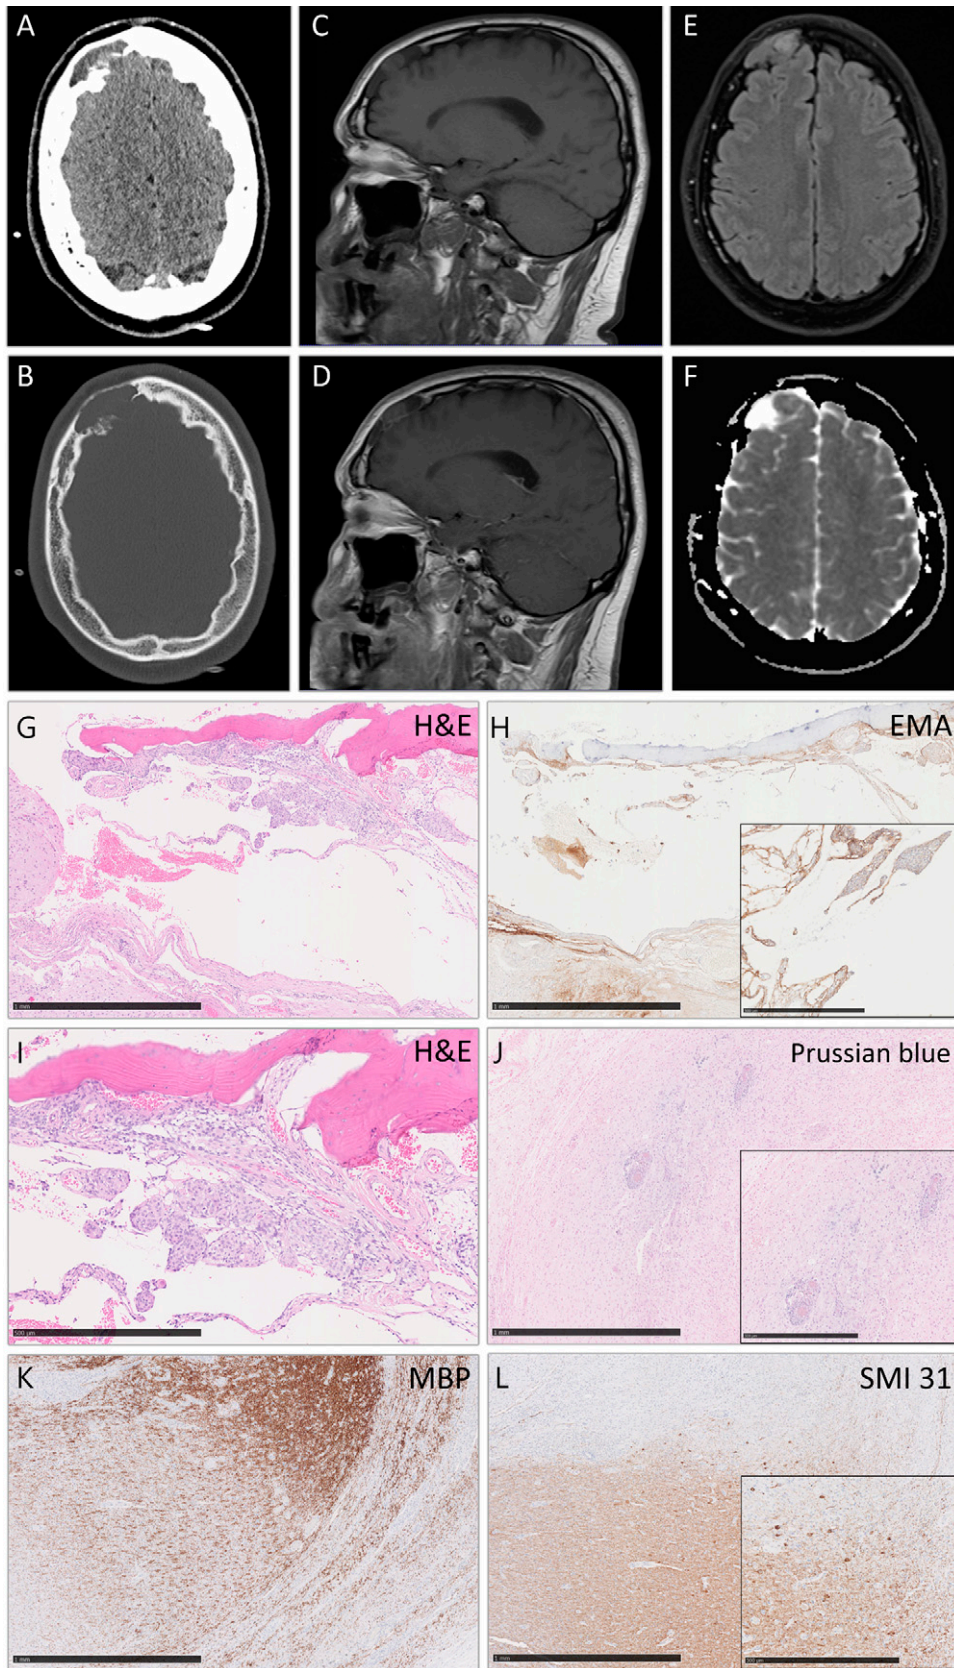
Axial bone window CT scan (A) displays the defective inner table and the widened diploic space in the right frontal skull. Furthermore, a short segmentally thinned outer table can be seen.
